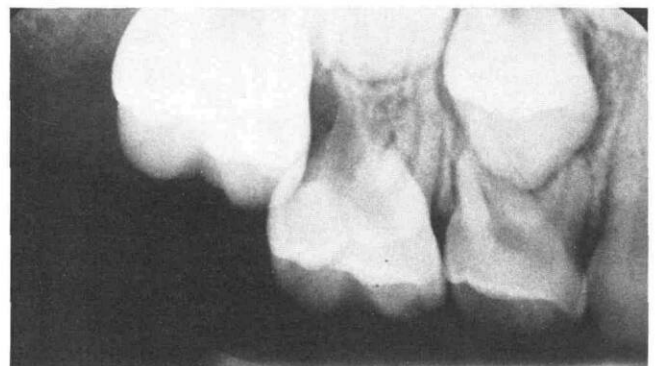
Radiograph of the ectopically erupting maxillary first permanent molar.
